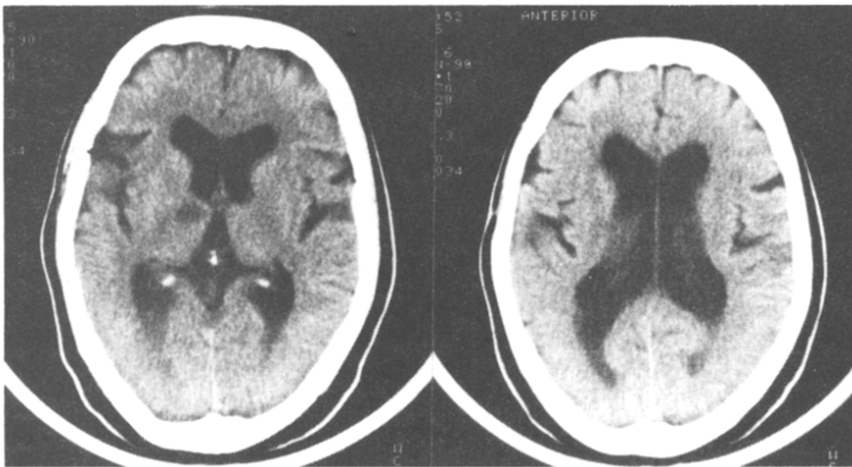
CT performed on the third day showed a low density area in the left ventral region of the thalamus.
